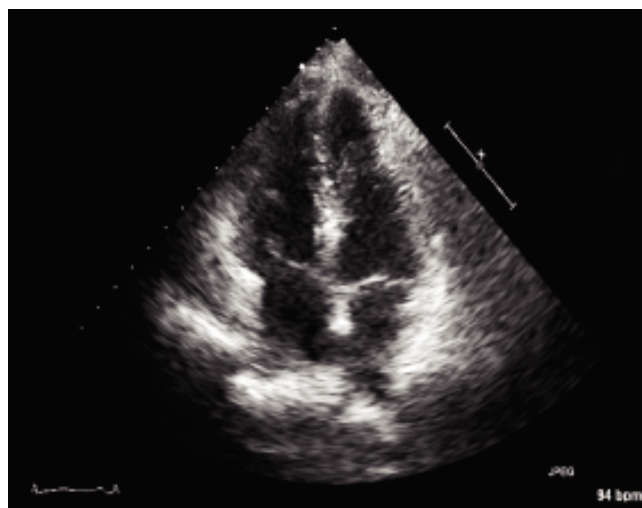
Post-operative echocardiogram showing resolution of compression.
